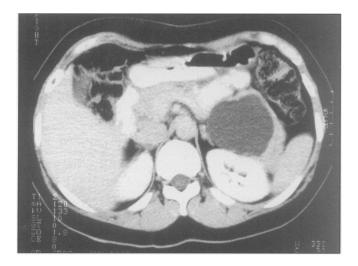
CT scan demonstrating a serous cystadenoma of the pancreas. Note the unilocular appearance with absence of any solid components.
